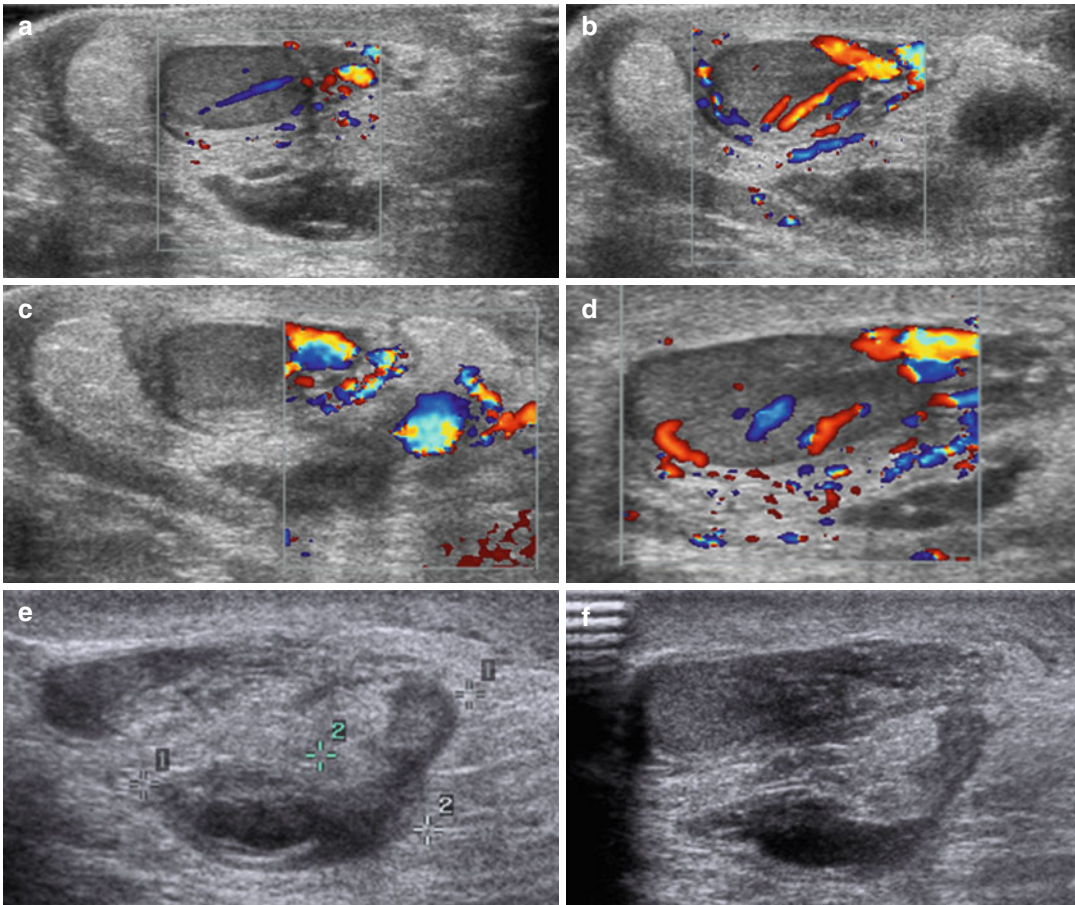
Color doppler scans (A,B,C,D)and ultrasound scans (E,F) in traumatic testicular lesion. Note the hemorrhagic swelling of soft tissues and scrotal bags and the posterior hematoma
